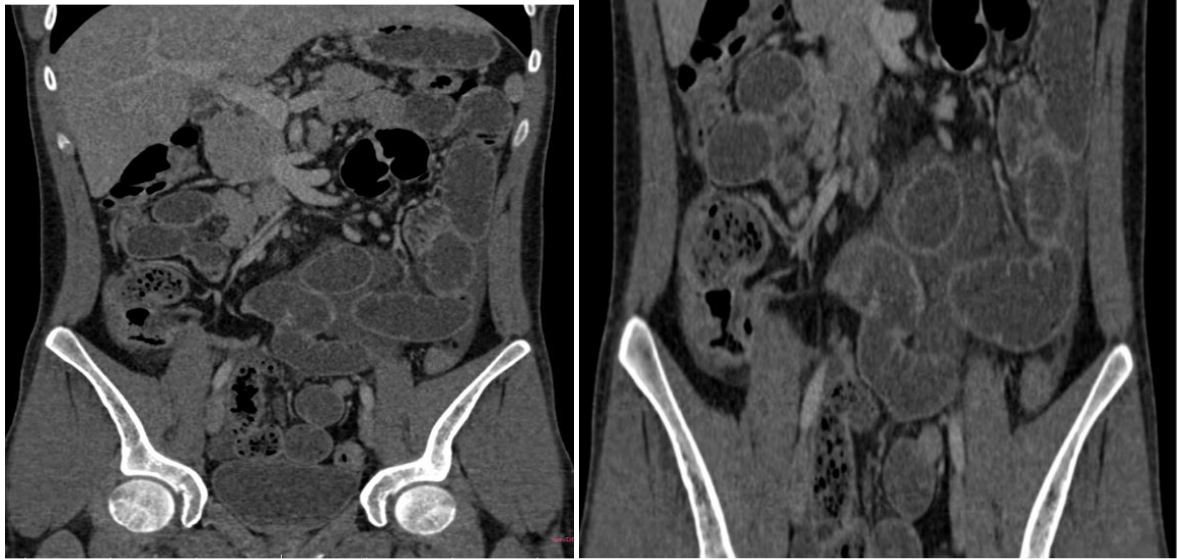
Contrast-enhanced CT of the abdomen showing a diverticular outpouching from the terminal ileal loop with teat-like thickening at the tip. A thin band-like structure is noted extending from the thickened tip towards the mesentery, suggesting a mesodiverticular band
